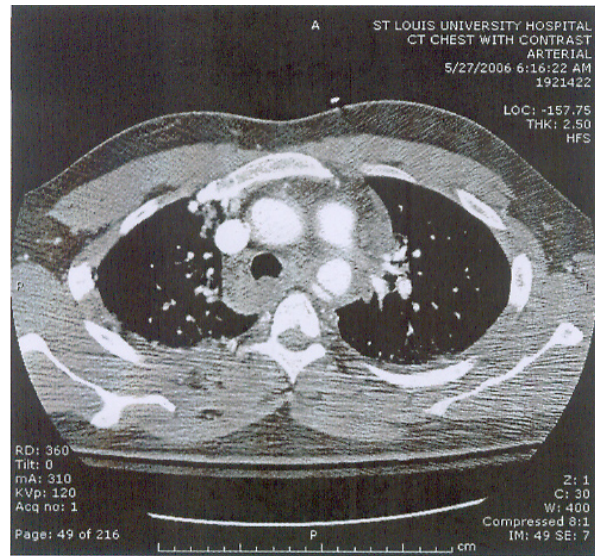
CT scan of acute descending thoracic transection with periaortic hematoma (arrow)
